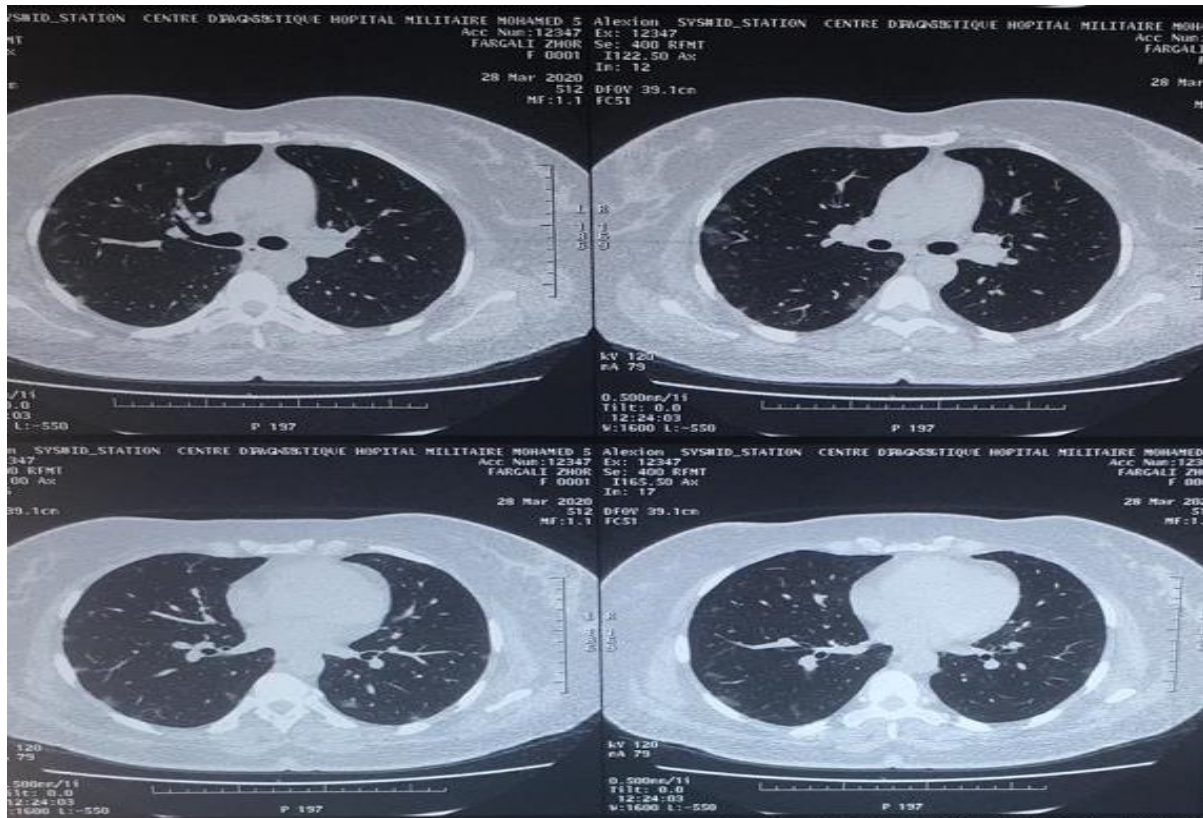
Chest CT scan on admission of a 50 years old female patient F.Z, that presented initially with dry cough, arthromyalgia and headache, with no underlying comorbidities.
